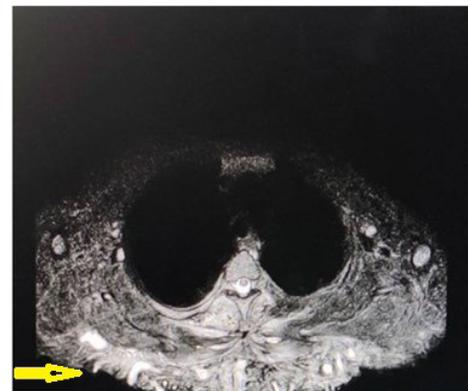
Magnetic resonance imaging: Multiple linear serpiginous hyperintense sinus tracts (yellow arrow) and abscess formation noted in the posterior upper back, involving the subcutaneous and superficial muscle plane.
